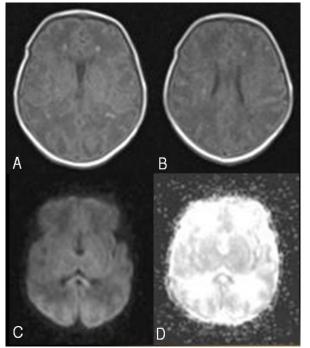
Axial T1WI (A, B), DWI (C) and ADC(D) showing multiple punctate foci of haemorrhage in bilateral cerebral white matter appearing hyperintense on T1WI and restricted diffusion in splenium with low ADC values
